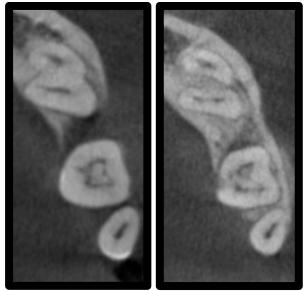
CBCT mandible, axial view, the *left* is more coronal 04.11.2013
